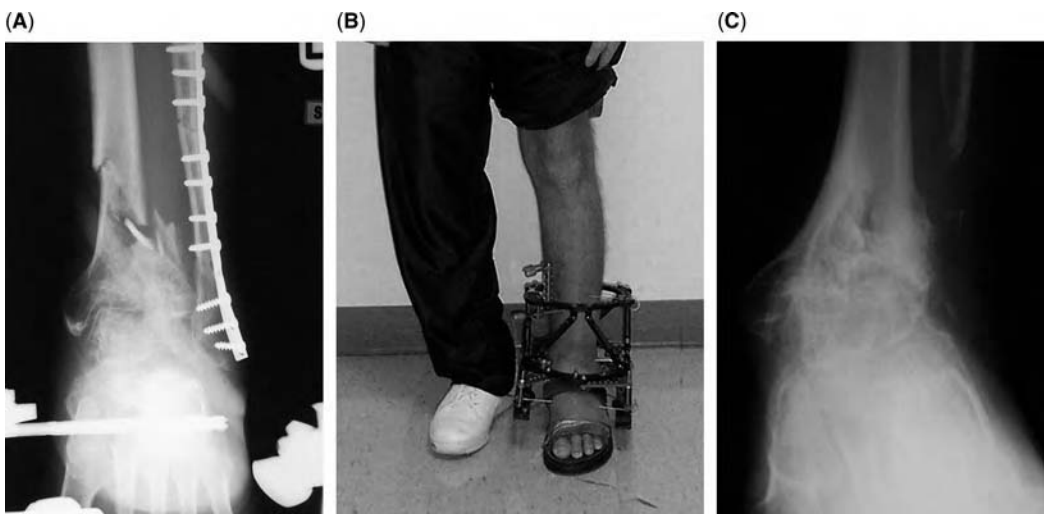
(A) Anteroposterior (AP) X-ray showing a pilon fracture nonunion nine months after trauma associated with advanced ankle arthrosis. This patient had been non-weight bearing in ankle spanning frame for nine months. (B) Front standing view showing an Ilizarov/Taylor spatial frame being used for simultaneous compression of the plafond nonunion and the ankle arthrodesis. (C) AP radiograph nine months after frame removal showing bony union.
